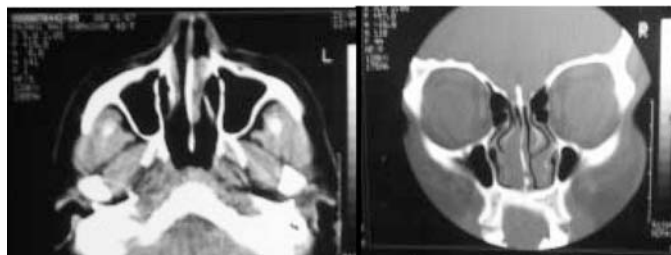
1. CT Scan axial and coronal cut showing homogeneous opacity in the left nasal cavity.
